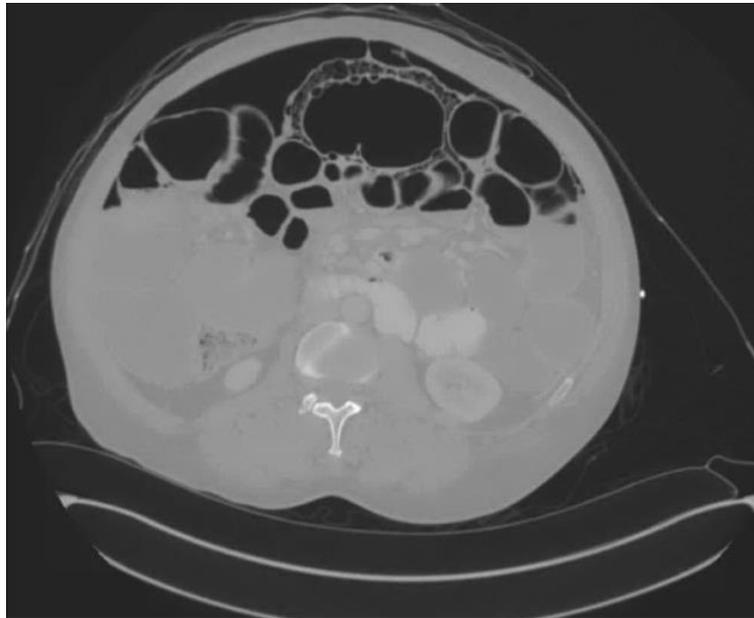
CT abdomen/pelvis shows pneumoperitoneum, pneumatosis intestinalis in ventral mid-abdomen, and evidence of small bowel obstruction.
